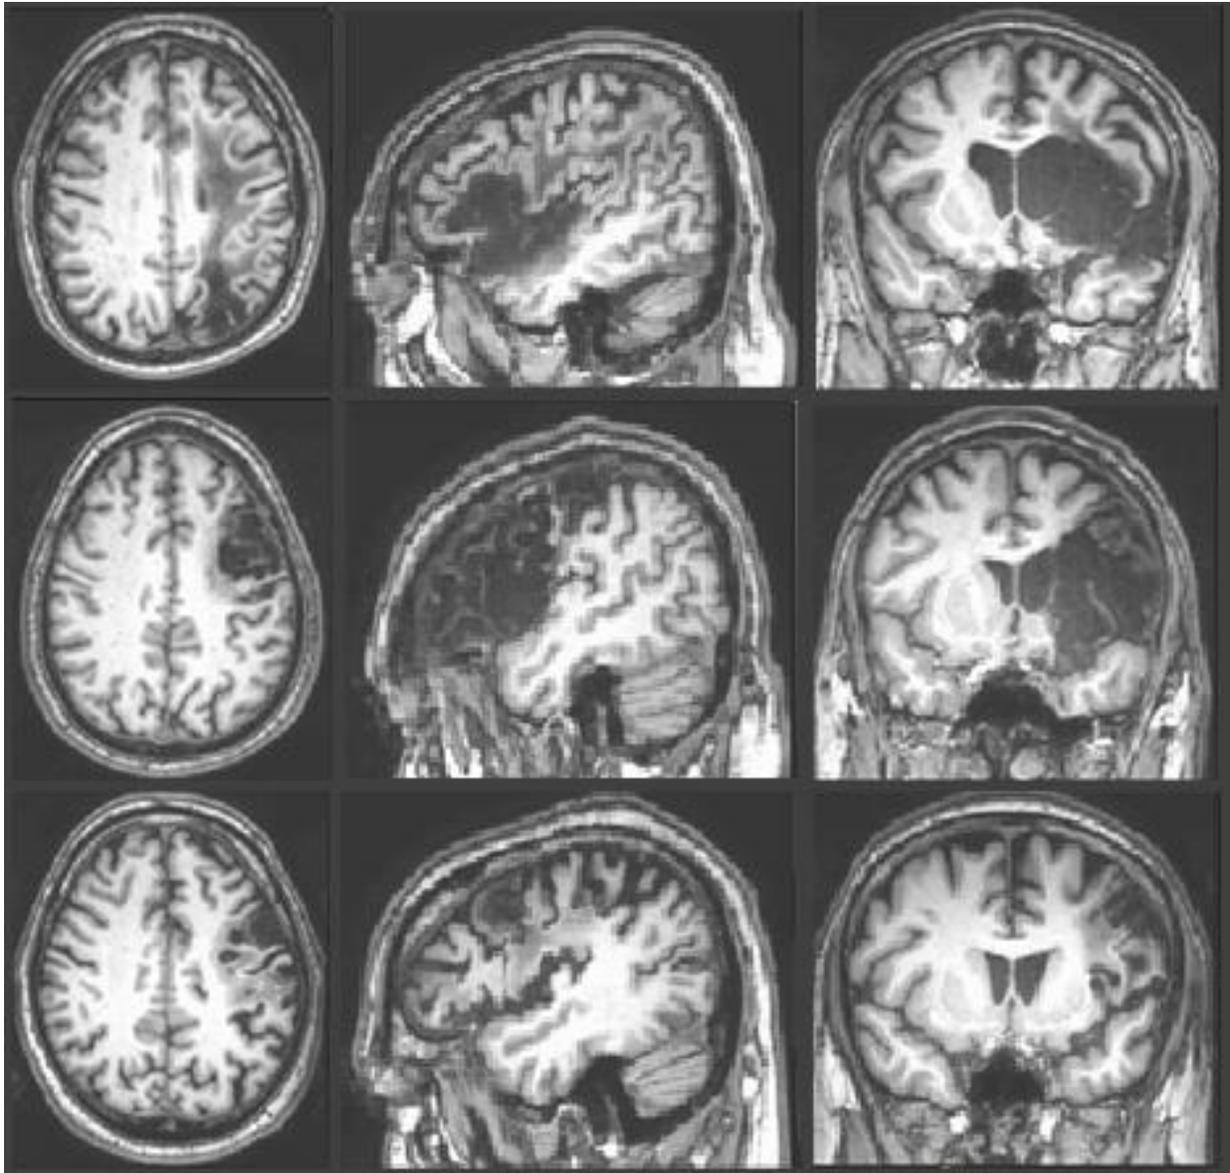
Magnetic resonance images for Participant1 (top row), Participant2 (middle row), and Participant3 (bottom row).
